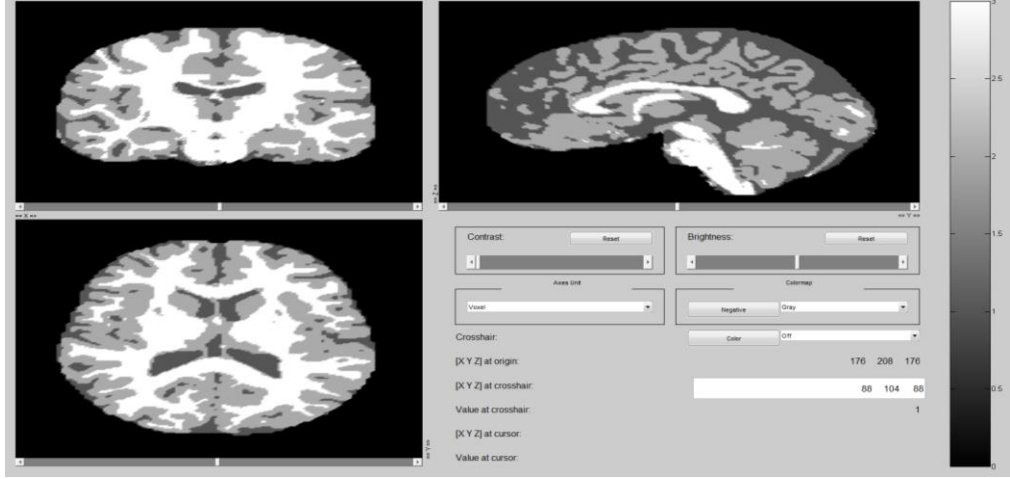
The Coronal, Sagittal and Axial views of the Brain MRI (segmented) at pixel position [88 104 88].
